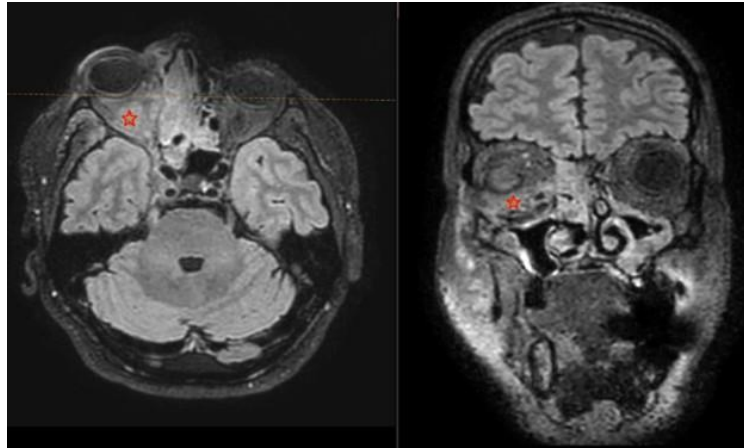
MRI brain for Case 1 (at presentation): The stars represent in the infection infiltrating the right orbital floor and the right inferior rectus muscle associated with air pockets (noted on the Coronal FLAIR image represented by the dark dots) and exophthalmos.
